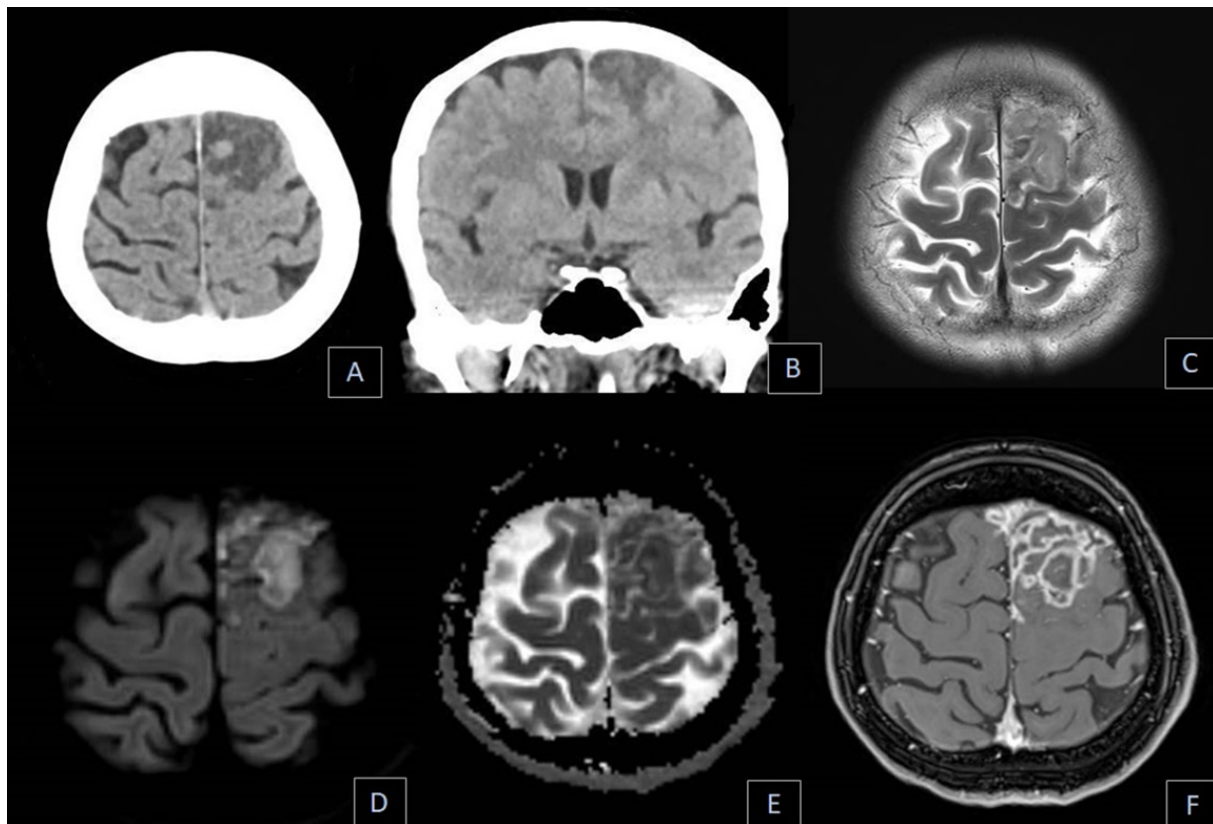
A 60-year-old female was shown with severe MR and infective mitral endocarditis. Axial and Coronal CT brain (A and B) demonstrates a well-demarcated hypodense lesion involving the parasagittal left frontal lobe. The patient underwent MRI two weeks afterward. Axial T2 weighted image (C), DWI (D), ADC (E) and post-contrast T1 weighted image (F) show persistent heterogeneous T2 hyperintensity of the left frontal lobe lesion with restricted diffusion and layering rim enhancement, likely representing cerebritis and abscess.
